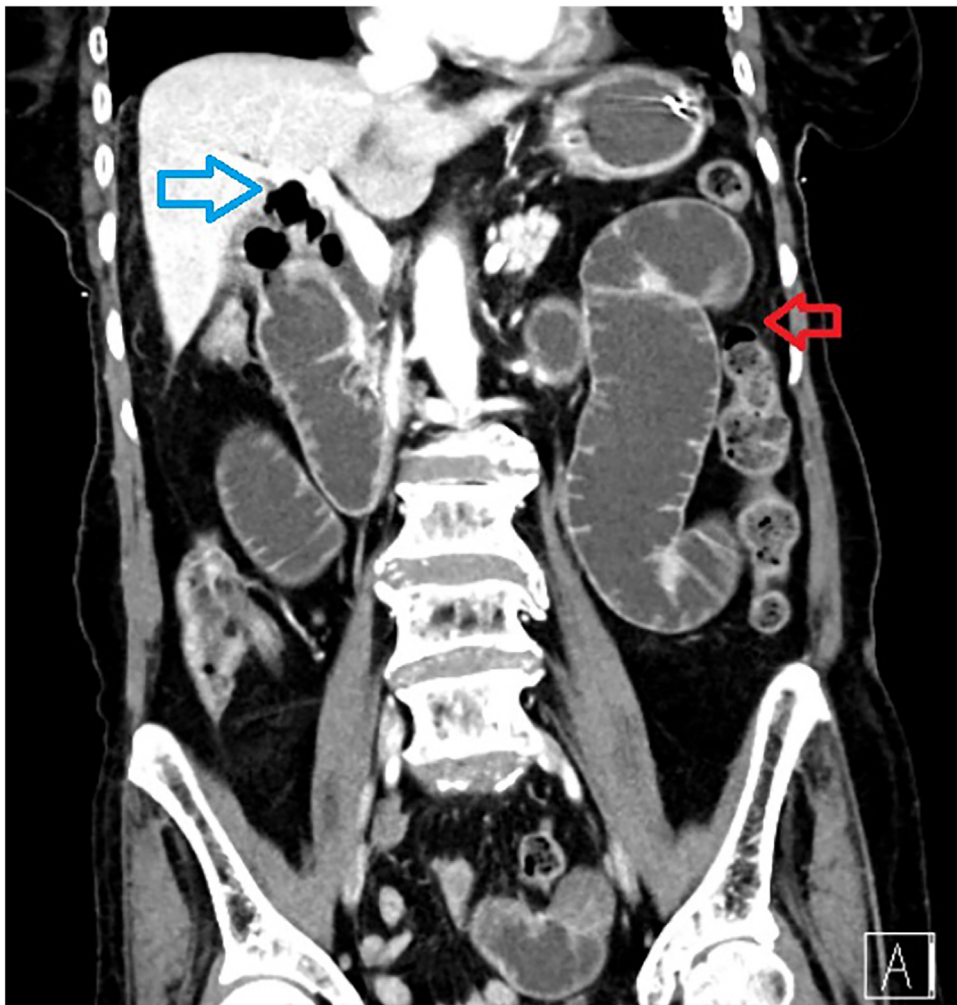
CT abdomen showing the classical Rigler's triad of GSI. The red arrow indicates the ectopic gallstones. The blue arrow indicates the pneumobilia. Also, notice the dilated small bowel loops.
